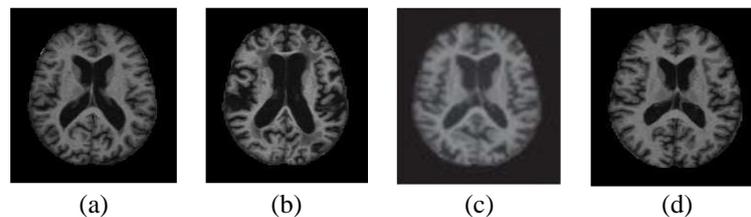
Brain MRI images for various stages of Alzheimer's disease: (a) cognitively normal (CN), (b) mild demented (MCI), (c) moderate demented (MD), and (d) very mild demented (AD)
